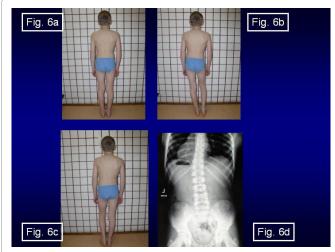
Standing 'at ease' test". (a) standing on both legs without influence on axis of spine. (b) standing 'at ease' on the left leg without influence on axis of spine or, if the scoliosis is present, beneficial influence on axis of spine. (c) standing 'at ease' on the right leg and if "permanent standing" cause of the scoliosis. (d) X-ray picture–the same child- showing "C" scoliosis in II/A epg.
